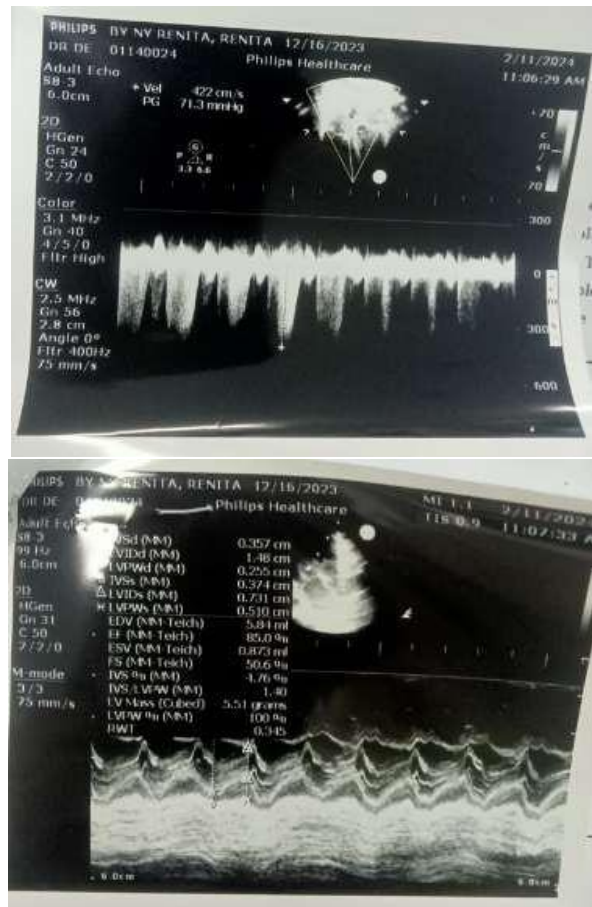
Echocardiographic
